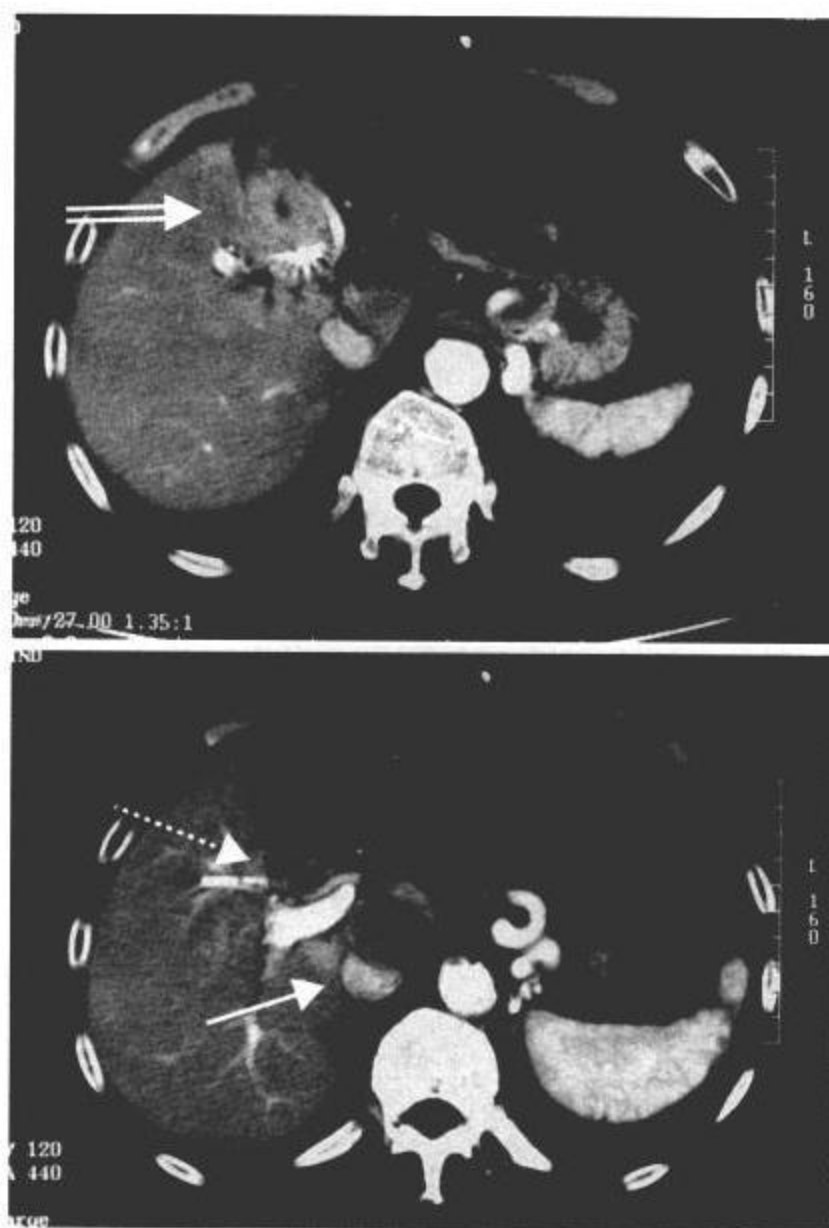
Computed tomography with enhancement. The tumors in the medial segment (white arrow) and caudate lobe (black arrow) with filling tumor thrombi in dilated biliary tract (black dot arrow) were noted. There were not any tumors detected in the right lobe.
